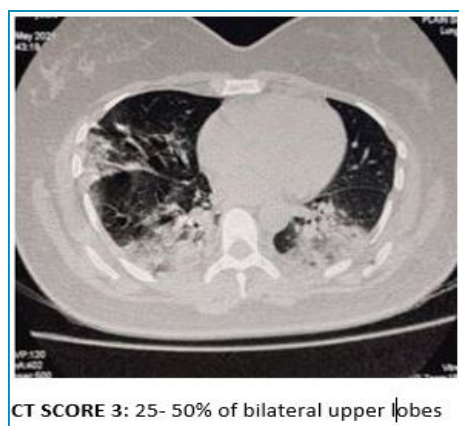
(b): CT severity score (3)
